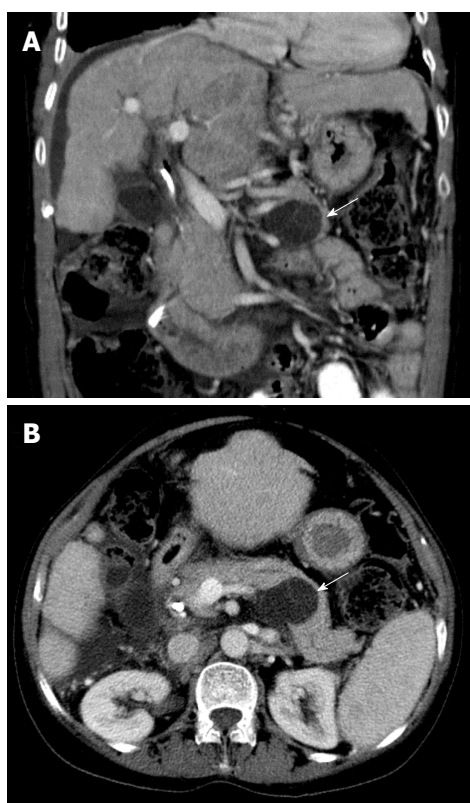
Coronal (A) and axial (B) computed tomography images in portal venous phase demonstrate a well-defined low density lesion in the body/tail of the pancreas measuring 40 mm in maximum transverse dimensions (white arrows). Thin septa are demonstrated within the cyst.
